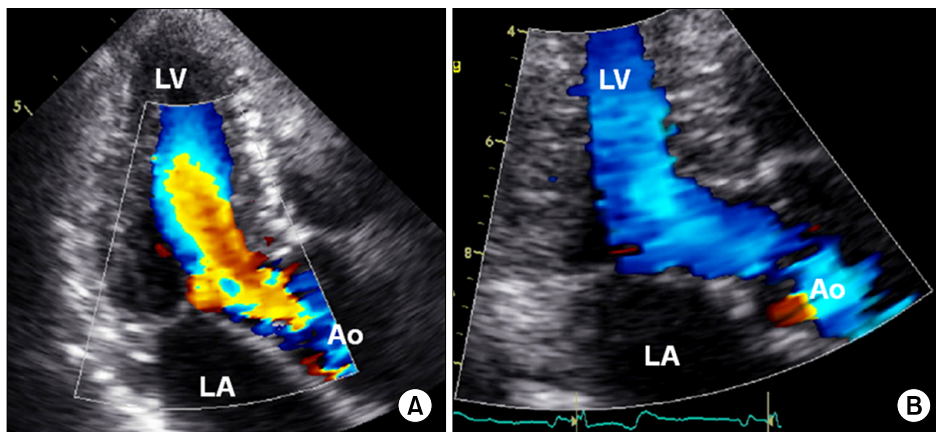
(A) Color Doppler image taken at the time of anemia (hemoglobin, 8.3 g/dL). Note the aliasing of color Doppler from the mid-level of left ventricular (LV) to LV outflow tract LVOT, suggesting flow acceleration and dynamic obstruction. (B) A color Doppler image at the LVOT after treatment. The systolic anterior motion of the mitral valve was abolished. Concurrently, this image shows a low-velocity laminar LVOT blood flow. The patient's symptoms were improved dramatically. LA, left atrium; Ao, aorta.
